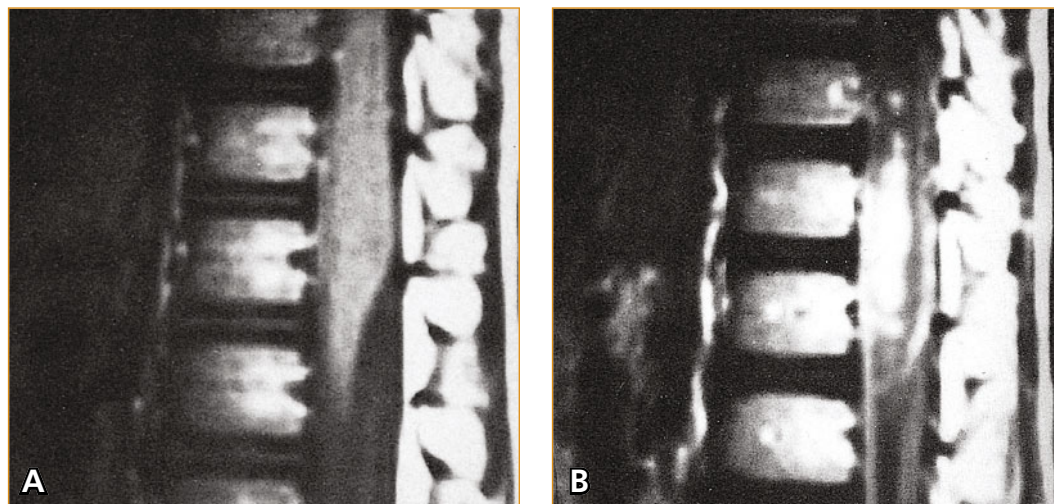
T1-weighted MRI showing sagittal view of a spinal cord in a case of *Schistosoma mansoni*. A, Pre-contrast MRI scan showing increased anteroposterior diameter of the spinal cord at T11–T12. B, Postcontrast MRI scan showing enhancement of the schistosomal lesion. Cerebral schistosomiasis may be acute or chronic. The acute form presents as fulminating meningoencephalitis with fever, headache, confusion, lethargy, seizures, focal deficits, and coma.
